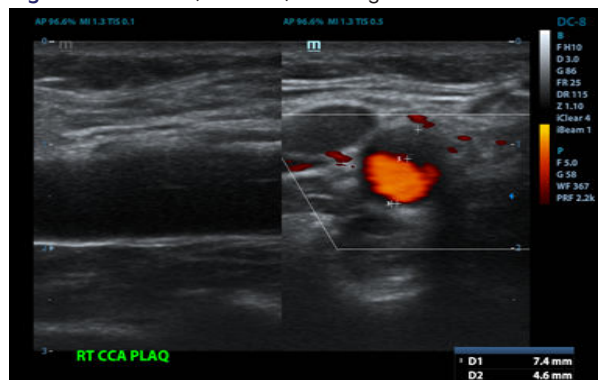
Carotid Doppler Showing Right Common Carotid Artery Plaque
